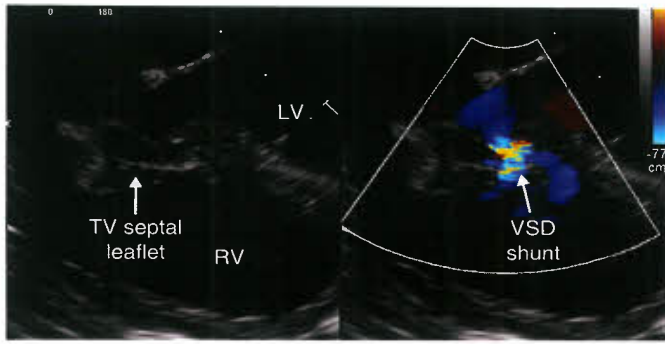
Transesophageal echo long-axis view of a perimembranous VSD interrogation prior to surgical closure. The left image demonstrates the relationship of the VSD to the aortic and tricuspid valves. The right image demonstrates left-to-right color Doppler flow.
